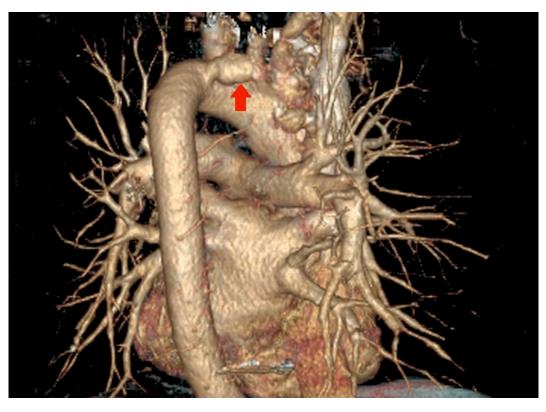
Pseudoaneurysm of the thoracic aorta shown in a 3D reconstruction from chest computed tomography scans
